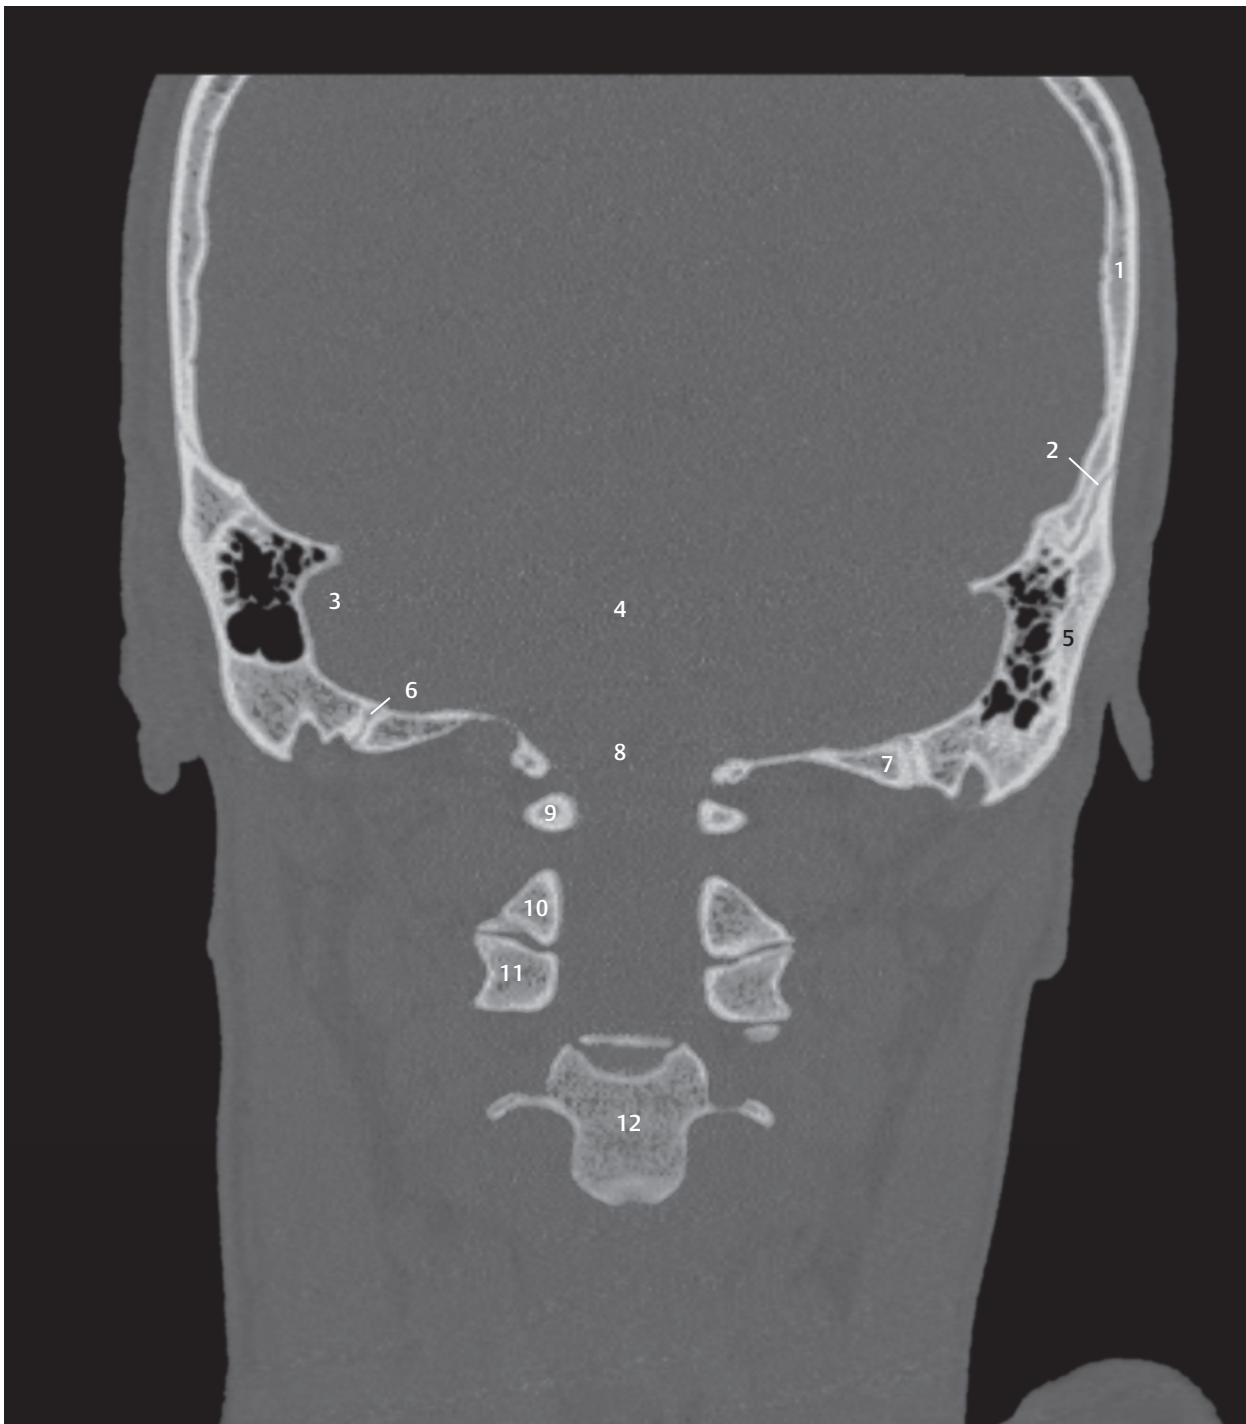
8th coronal section. CT image, mildly posteriorly positioned than the 8th coronal section. The internal auditory canal, facial canal, and mastoid air cells are visible in the petrous part of the temporal bone. The first three cervical vertebrae are well seen.
